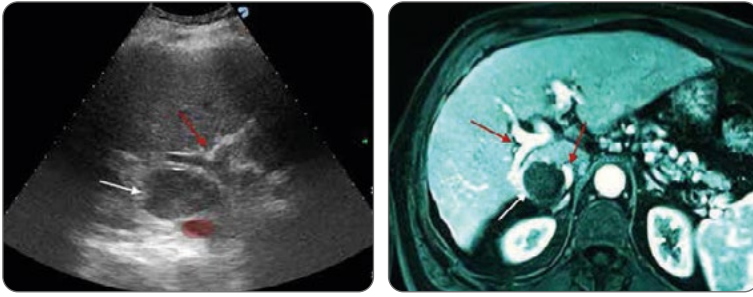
a) a partially exophytic HCC (white arrow), located between a branch of the portal vein and the vena cava, was completely ablated without any alterations to the surrounding vascular structures; b) MR image at one-month follow-up showing complete ablation (white arrow). *Images by courtesy of Dr. Giovan Giuseppe Di Costanzo (Cardarelli Hospital, Naples).*
